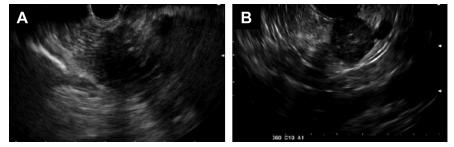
Endosonographic appearance of an adenocarcinoma (*A*) and a neuroendocrine tumor (*B*) in the tail of pancreas. The adenocarcinoma has poorly defined irregular margins compared with the well-defined round contour of the neuroendocrine tumor.
